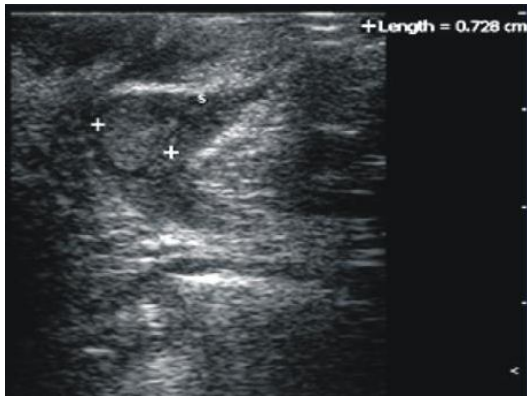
Ultrasound Scrotum showing Normal Testicle, Hypoplastic Penis.
